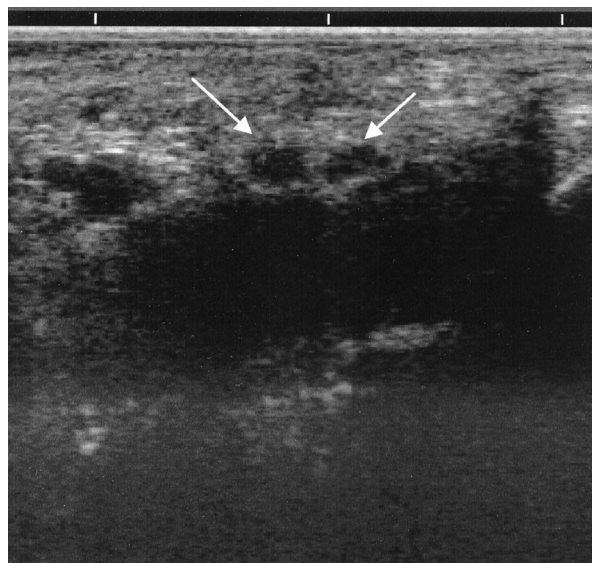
In this ultrasonographic image of the patient (axial section), the *arrows* point to the bifid median nerve.
